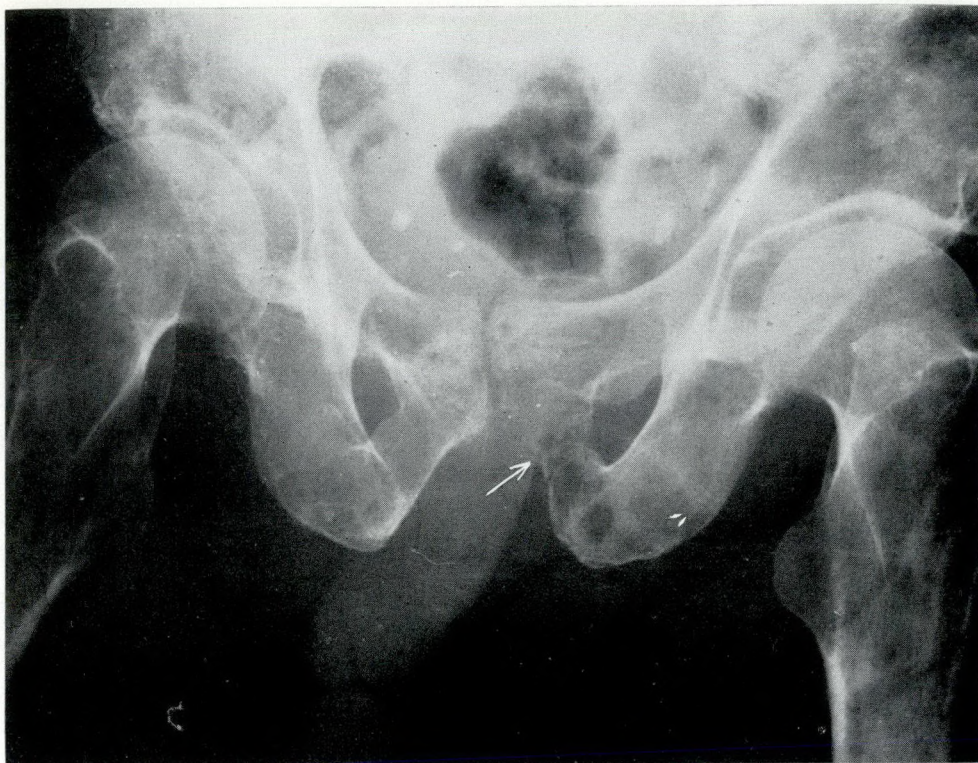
Radiograph of pelvis and femurs. Note destructive lesion in left pubic arch.
